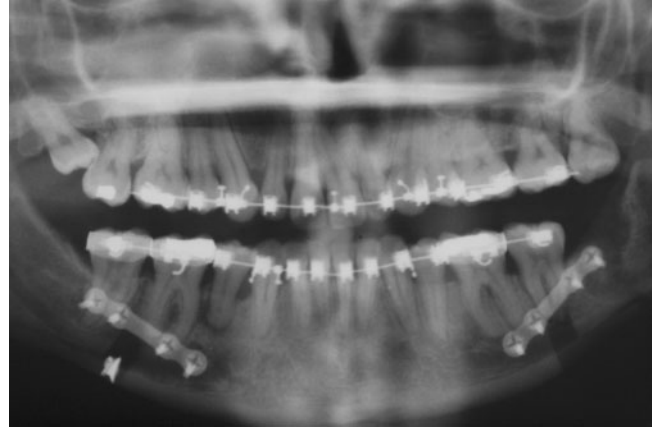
HF orthopantomogram
